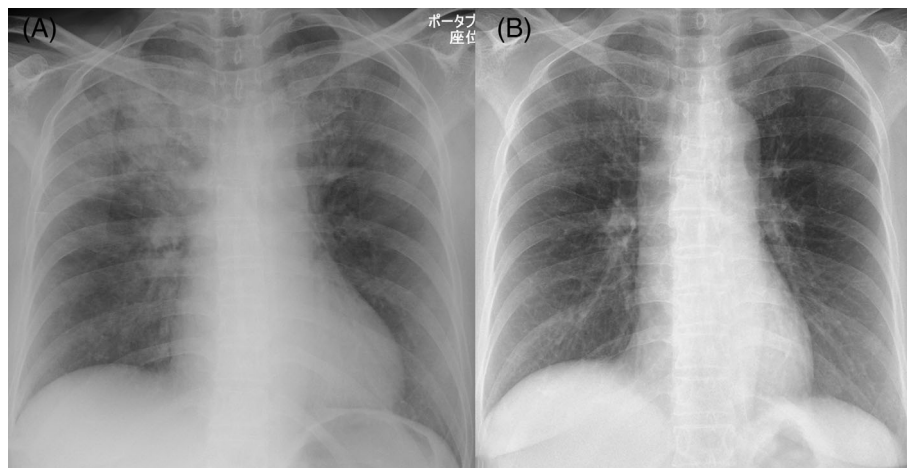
A series of chest radiographs show rapid improvement of infiltrative shadow in both upper lungs. (A) Chest radiograph immediately on admission. (B) Chest radiograph on the second day post admission
